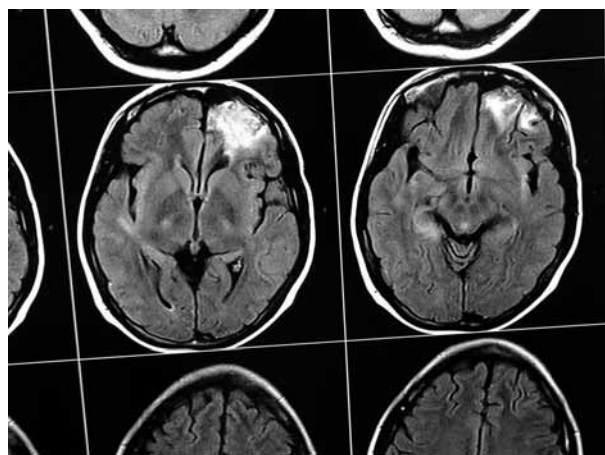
Magnetic resonance imaging, mass lesions were detected in right frontal and left posterior parietal lobes.
